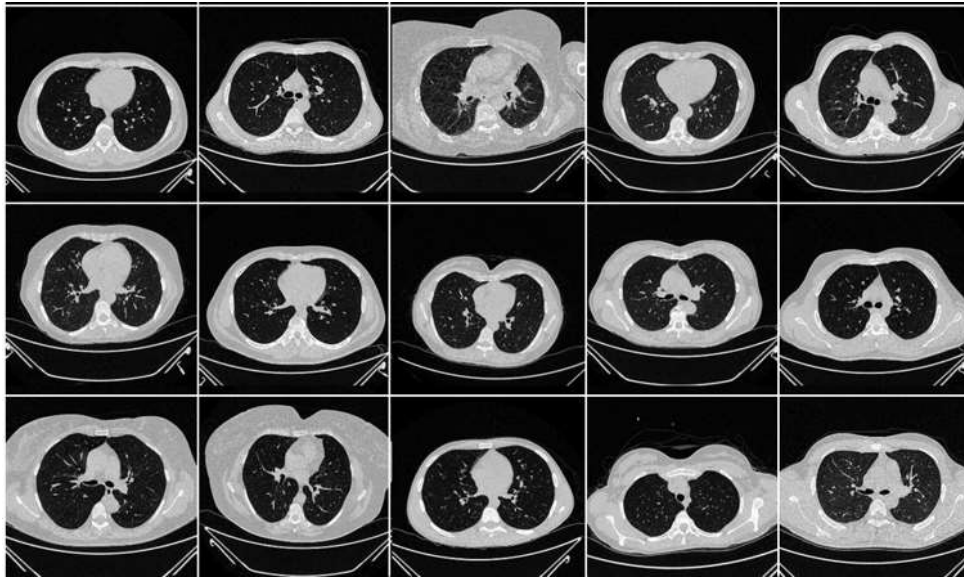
Raw “Control CT slices” taken from the NovMED dataset.
